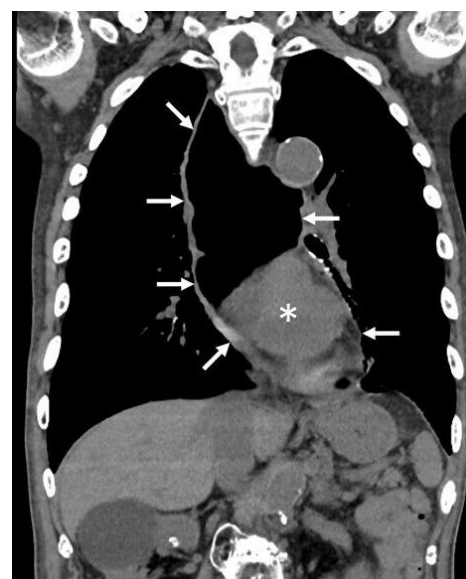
Chest computed tomography revealing severe dilatation of the esophagus (arrows; an asterisk indicates the heart) (reprinted with permission of the patient's family)
